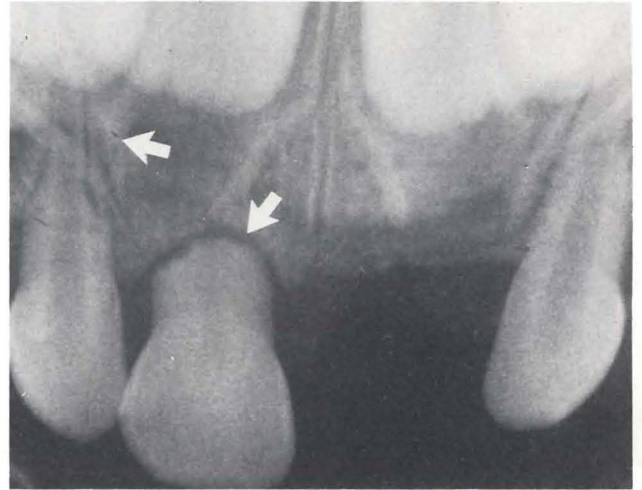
Periapical radiograph of case 1, three years after surgery, indicating atypical root resorption of maxillary left incisors (viewed from the lingual).
